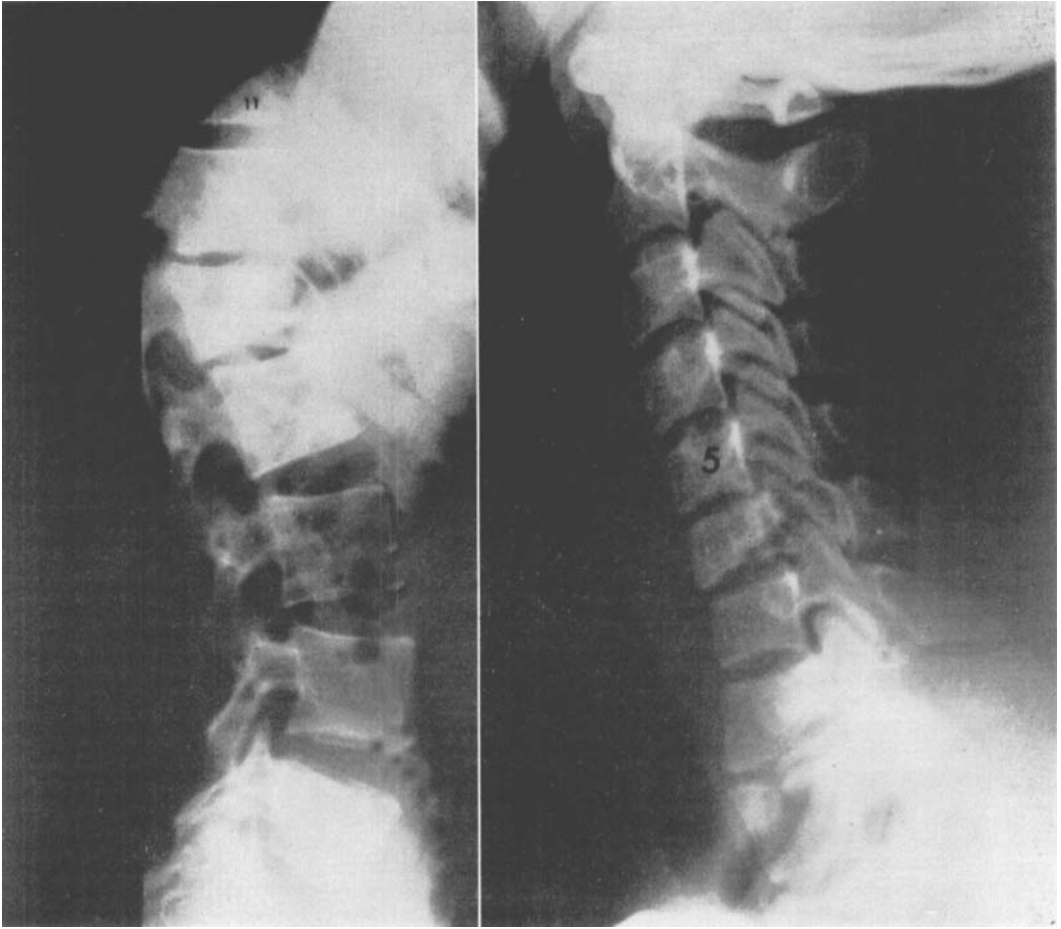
(Case 4). A. Left—x-ray of thoracic spine at the time of admission revealed wedge compression fracture of L_1 vertebral body. B. Right—x-ray of cervical spine showing wedge fracture of C_6 and subluxation of C_6 on C_7 .
